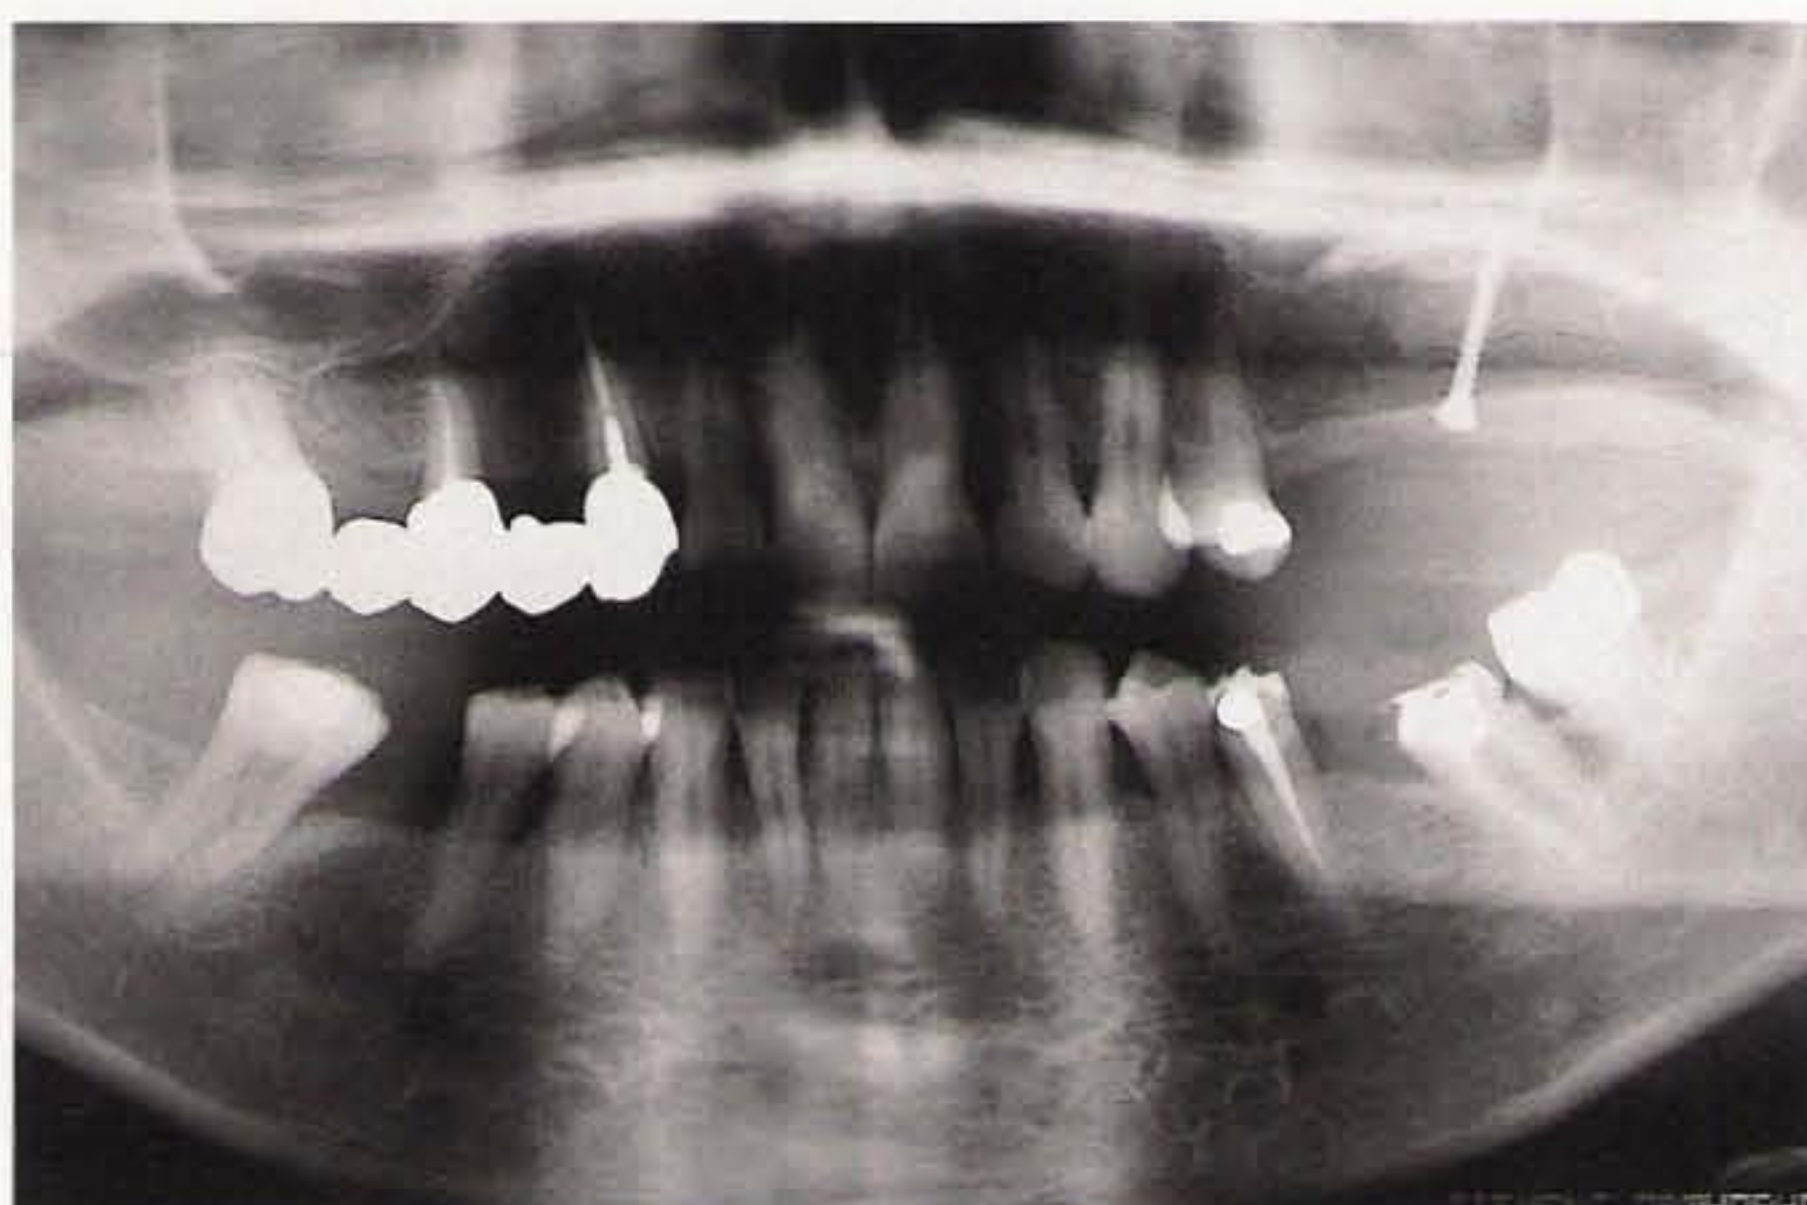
Control panoramic radiograph after 6 months. The grafted block, stabilized with screws, is clearly visible.
